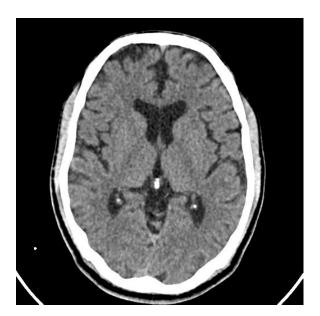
CT scan image of the patient showing generalized cerebral atrophy.
